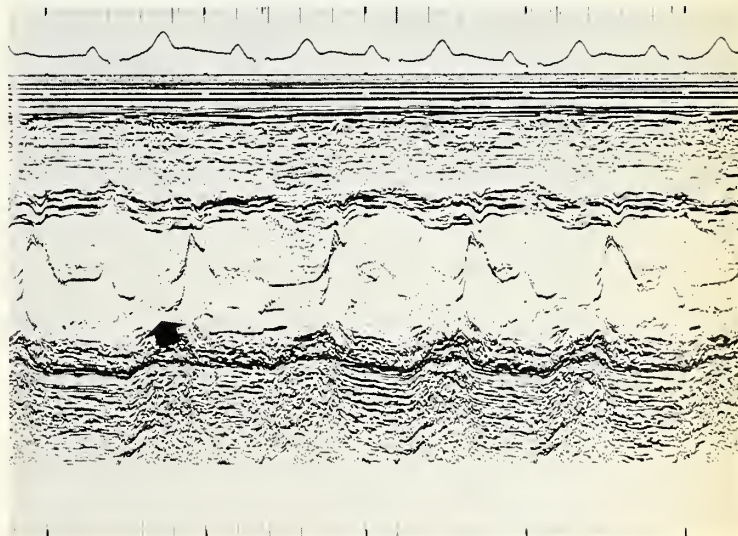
Echocardiogram shows hammocking of the mitral valve in late systole (arrow).
